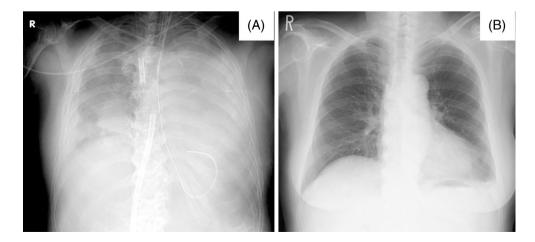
Chest radiographs (A) immediately after the introduction of ECMO showing worsening of the diffuse infiltration than at admission and (B) at discharge showing almost normal appearance
